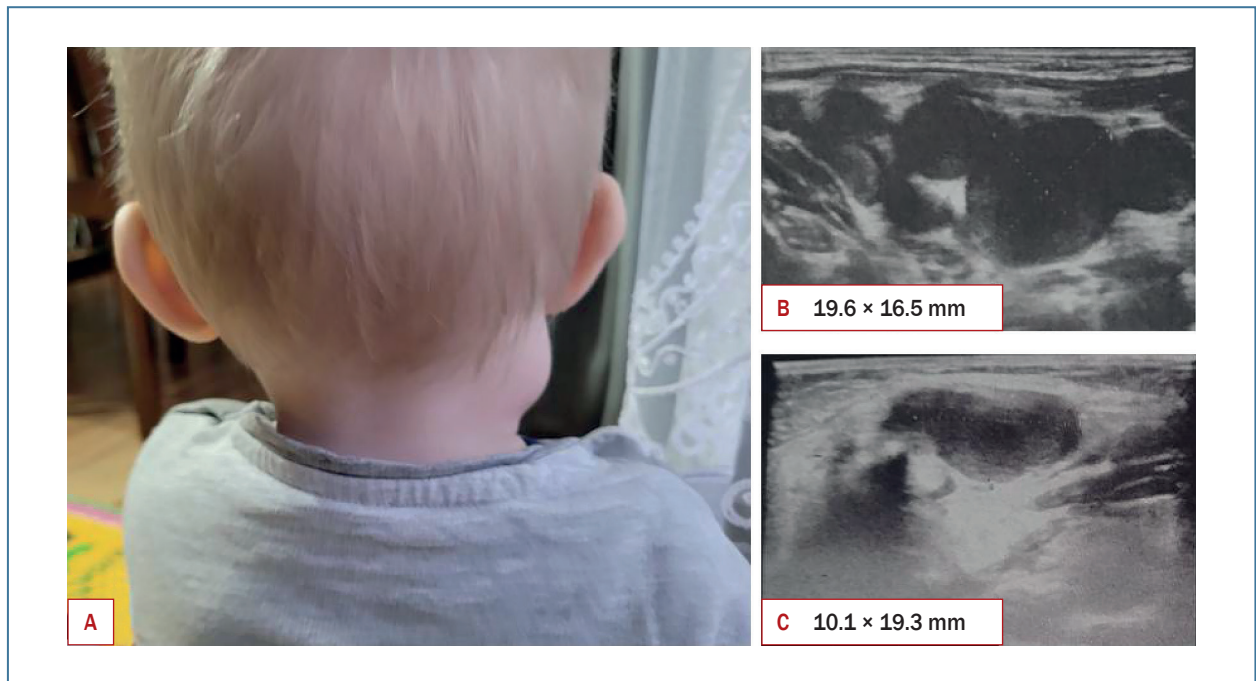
Manifestation of lymphadenopathy: in clinical examination (A), ultrasonography of right cervical lymph nodes (B) and right sub-mandibular lymph nodes (C)
